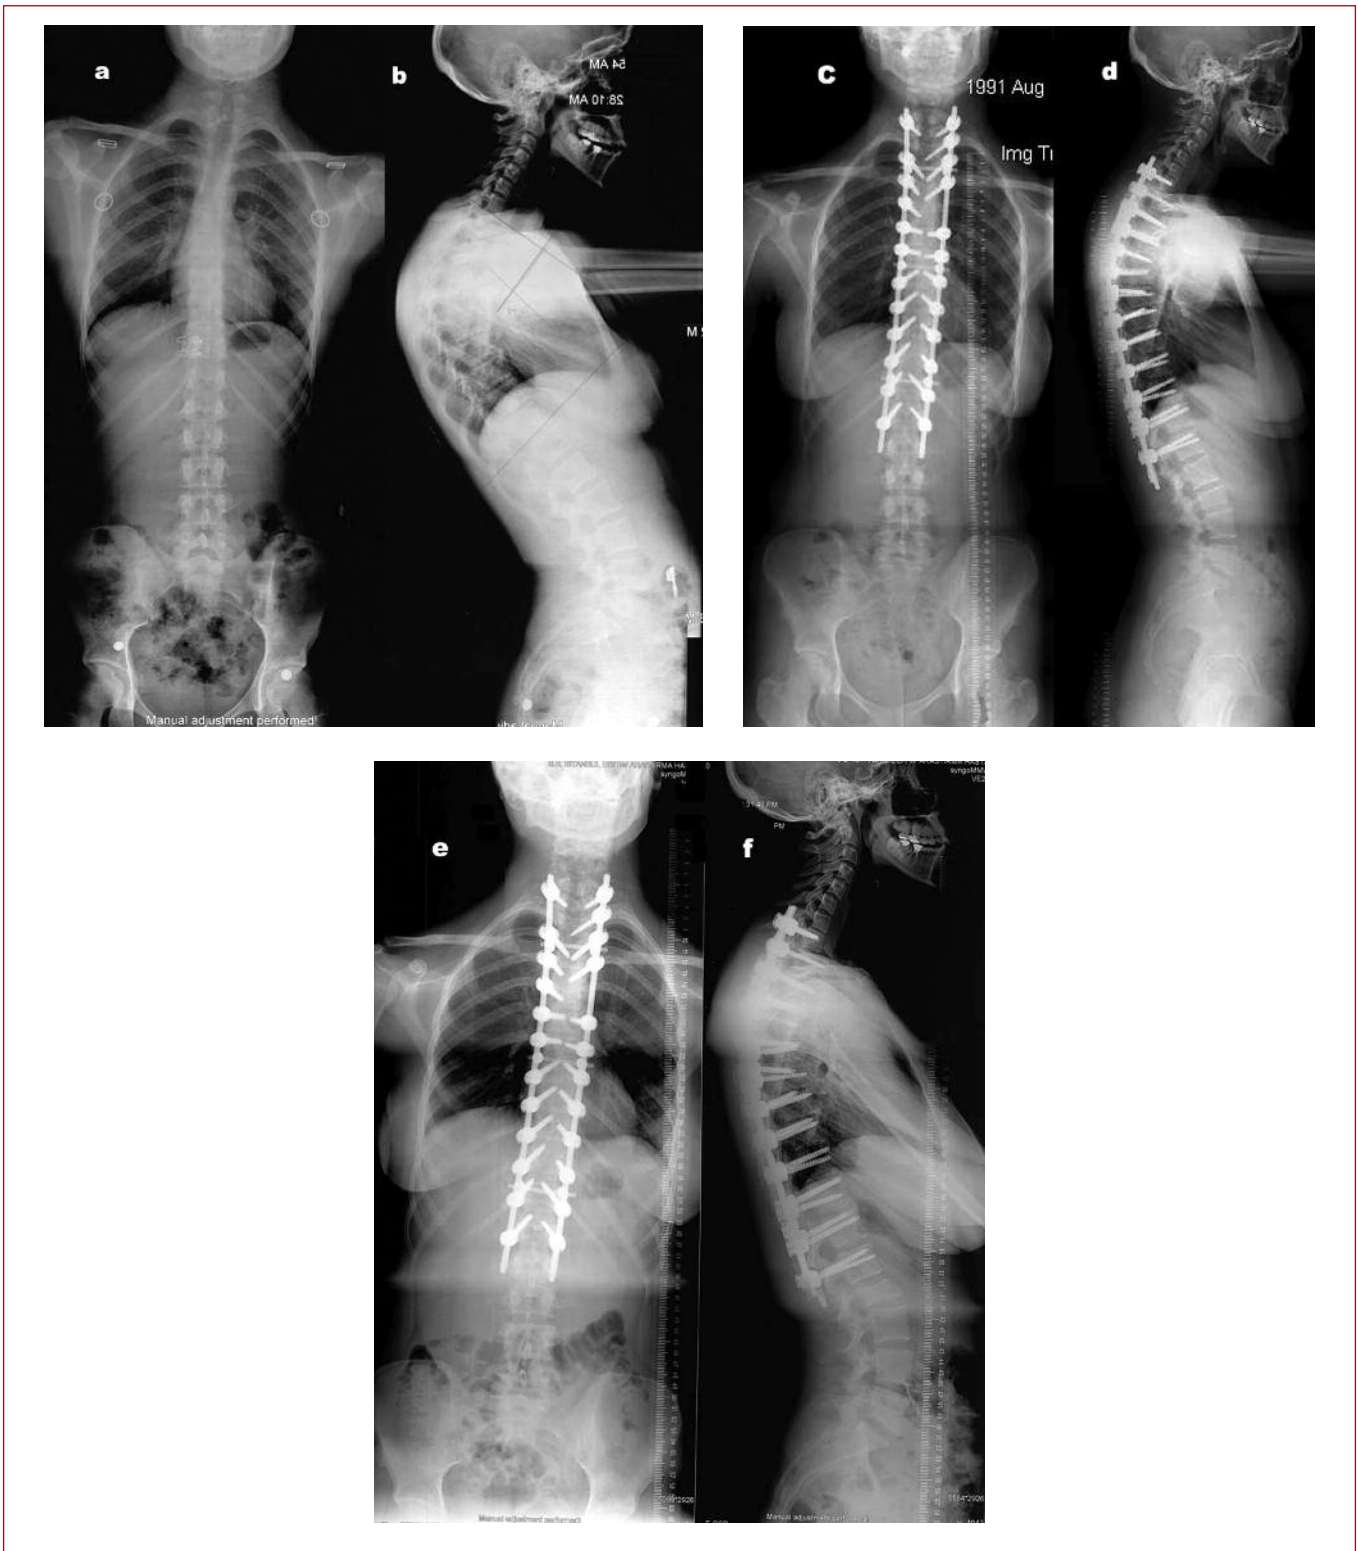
a. Antero-posterior and b. lateral X-rays of an 18-year-old female patient before surgery, c. Antero-posterior and d. lateral X-rays of the same patient after surgery, e. antero-posterior and f. lateral X-rays at last follow-up
